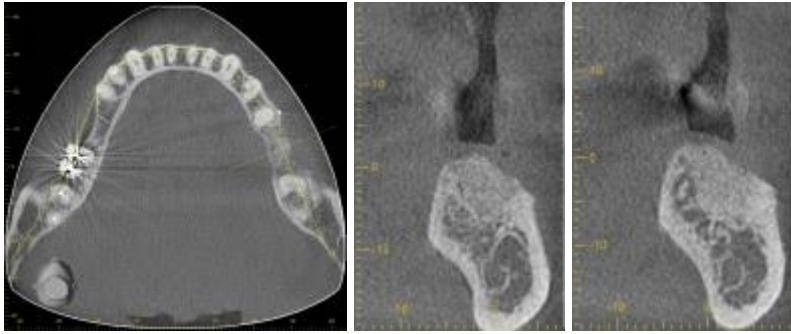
Section X-rays of tooth area 36
